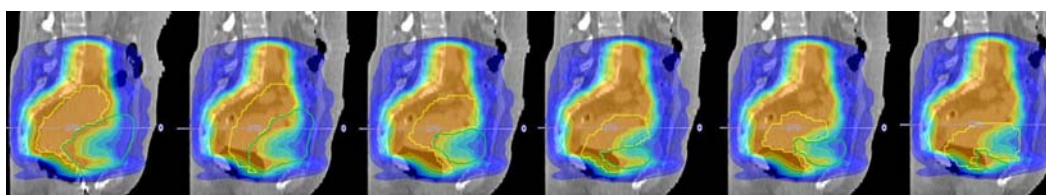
Planned dose distribution based on the planning-CT and changing uterus positions for different bladder filling stages during the treatment fractions. The yellow contour depicts the uterus while the green one shows the bladder. [courtesy by webpage of Christian Doppler Laboratory for Medical Radiation Research and Radiation Oncology ¹]
